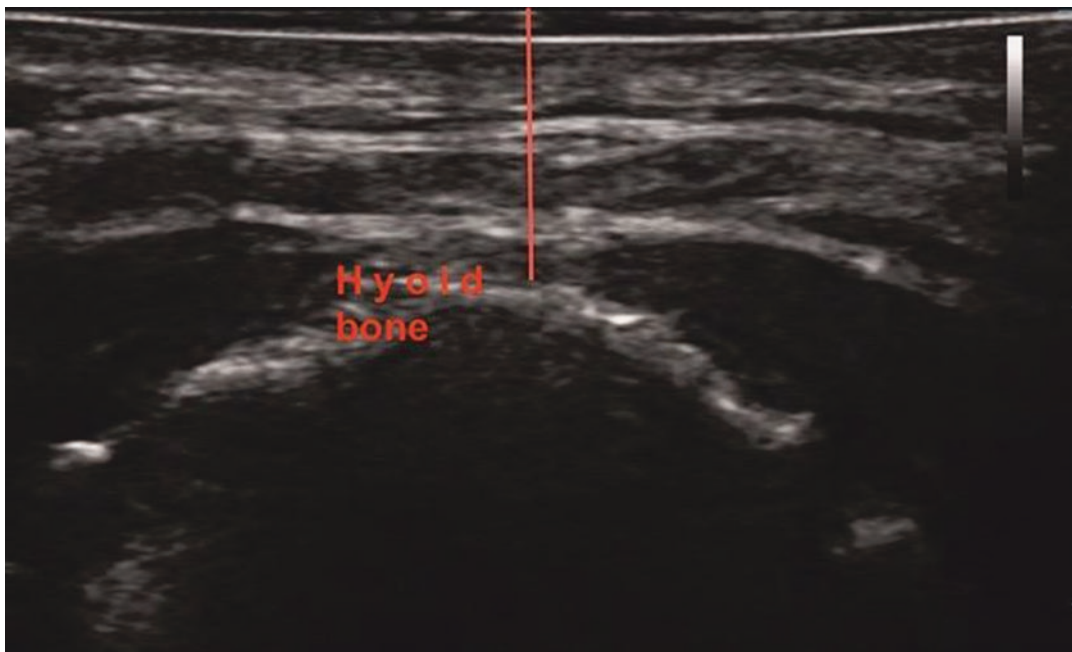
Ultrasound of neck at the level of hyoid showing the vertical distance from skin (red line)
